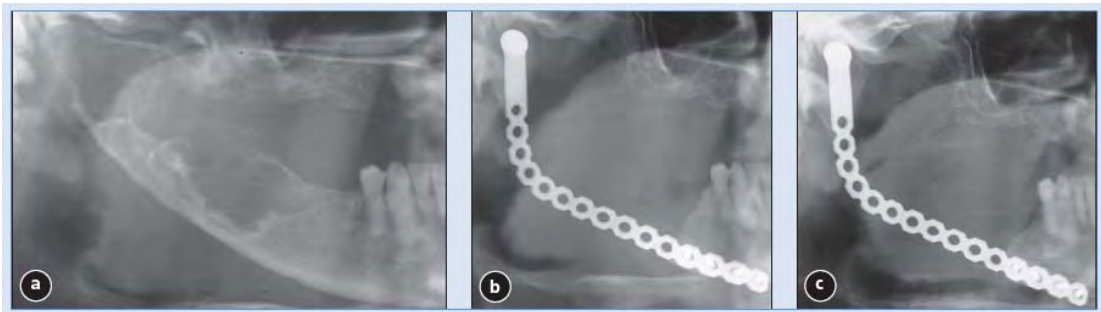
Partial panoramic radiograph taken (a) pre-operatively and (b) 6 days and (c) 6 years after resection.
